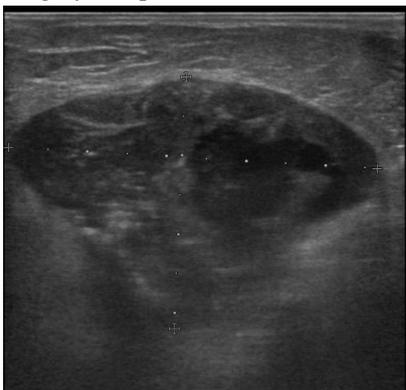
Superficial tissue ultrasonography shows; A lesion consistent with necrotic lymphadenopathy in the right axillary lobule with a diameter of 4 cm
